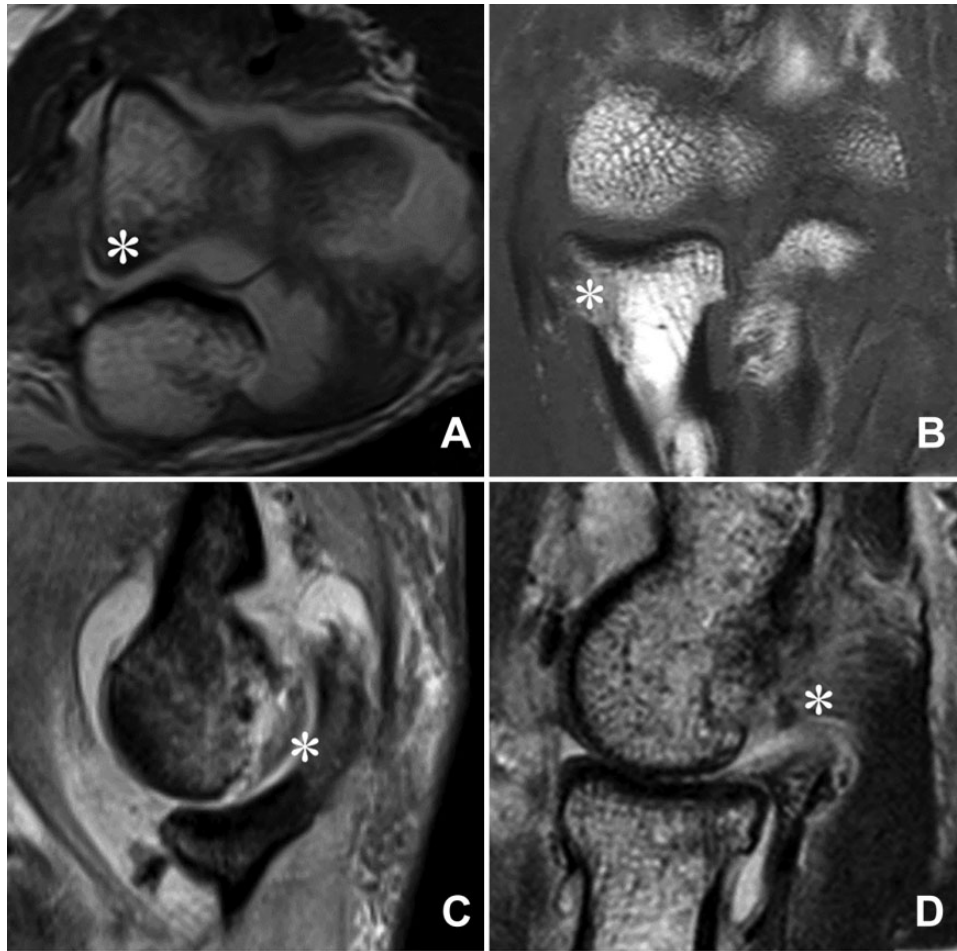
Osteochondral lesion stages on magnetic resonance imaging in patients with simple elbow dislocation. (A) Stage I: osteochondral lesion in the posterior trochlea with only subchondral edema. (B) Stage II: osteochondral lesion in the radial head, which was partially detached with edema. (C) Stage III: osteochondral lesion in the posterior trochlea, which was fully detached as a free osteochondral fragment. (D) Stage IV: osteochondral lesion in the posterolateral capitellum as a loose body. Osteochondral lesions are marked by an asterisk (*).
